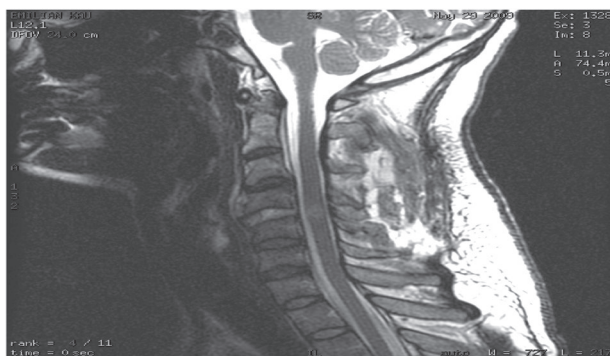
MRI after the surgical approach.
